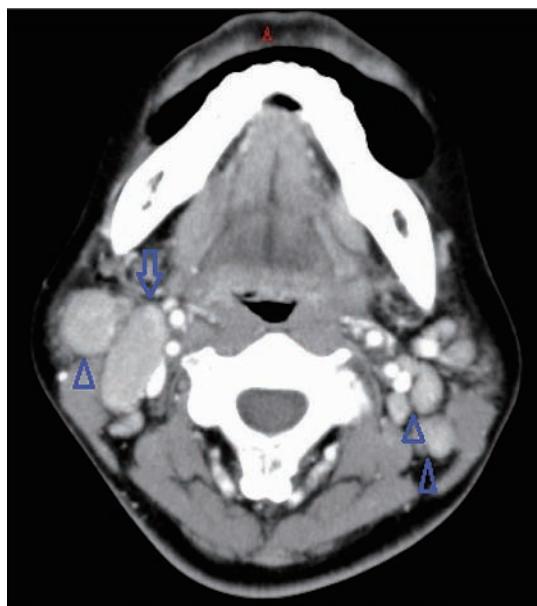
Head and neck computed tomography (CT) showed multiple enlarged lymph nodes over the bilateral parotid and carotid areas, and the posterior triangle of the neck regions (arrowhead). The largest one was about 3.2 cm in diameter (arrow).
